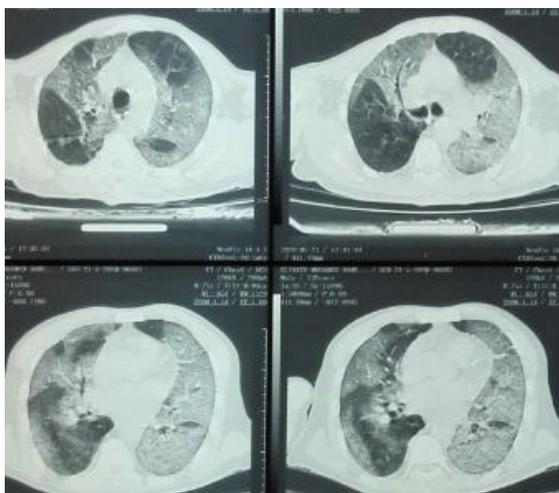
Axial CT images shows remaining one-third of healthy lung tissue with consolidation and crazy paving sign.
